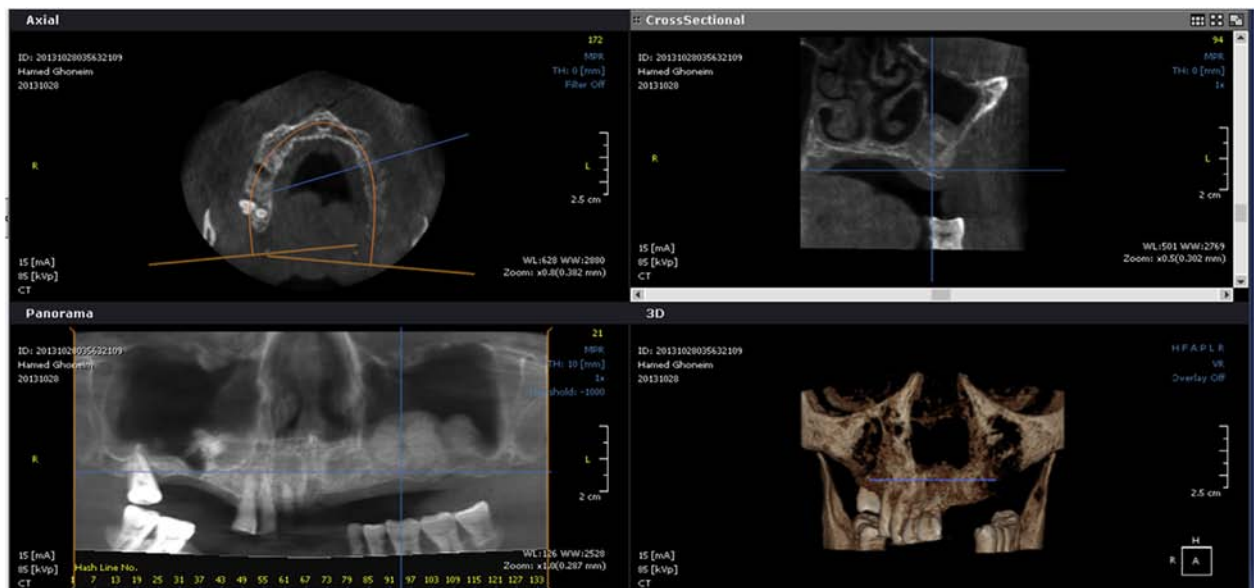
CBCT after 4 months is performed before implant placement for planning of the required implant length and diameter and to assess the amount of bone and its density.
